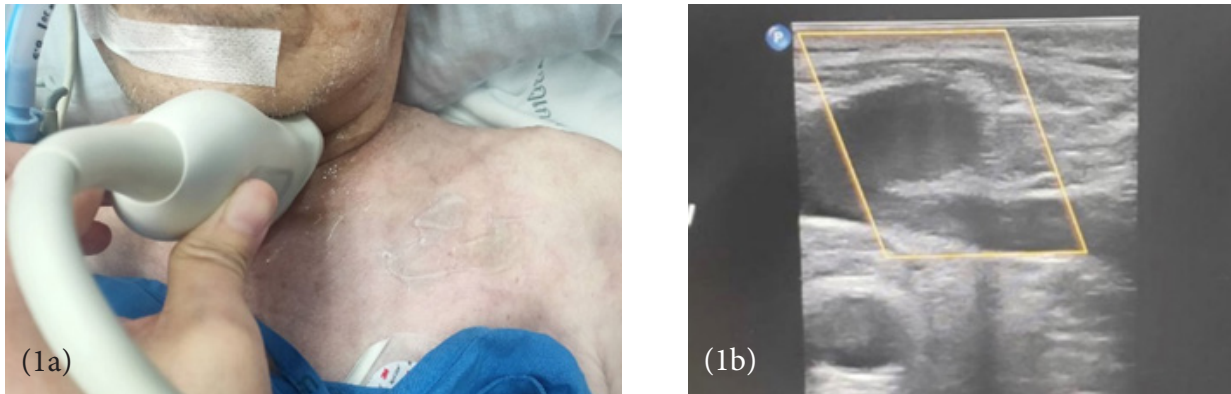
Probe position for evaluating brachiocephalic vein (1a), and ultrasonographic imaging of brachiocephalic vein (junction between internal jugular vein and subclavian vein) in B-mode (1b).
